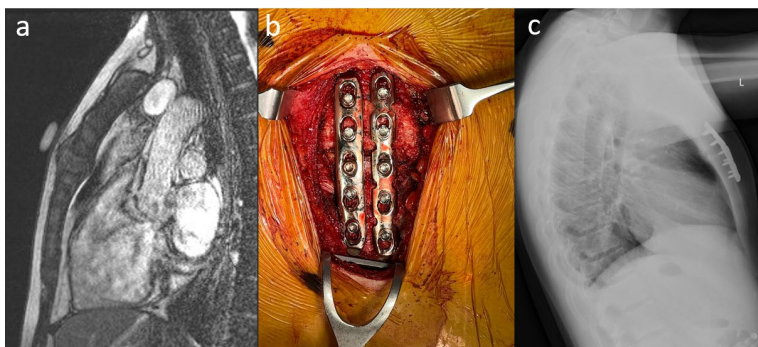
a) Coronal section of pre-operative MRI with skin marker over point of maximal discomfort, b) Intra-operative imaging of sternal plates c) Lateral chest x-ray post-operatively
